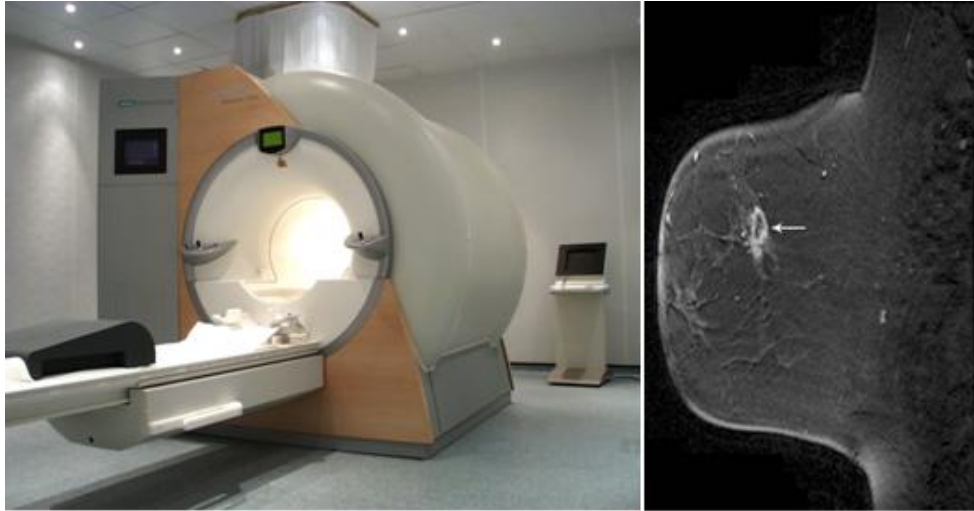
The MRI equipment and an MRI picture, there the arrow points to a high-density, irregular mass that indicate cancer.<sup>193, 194</sup>
